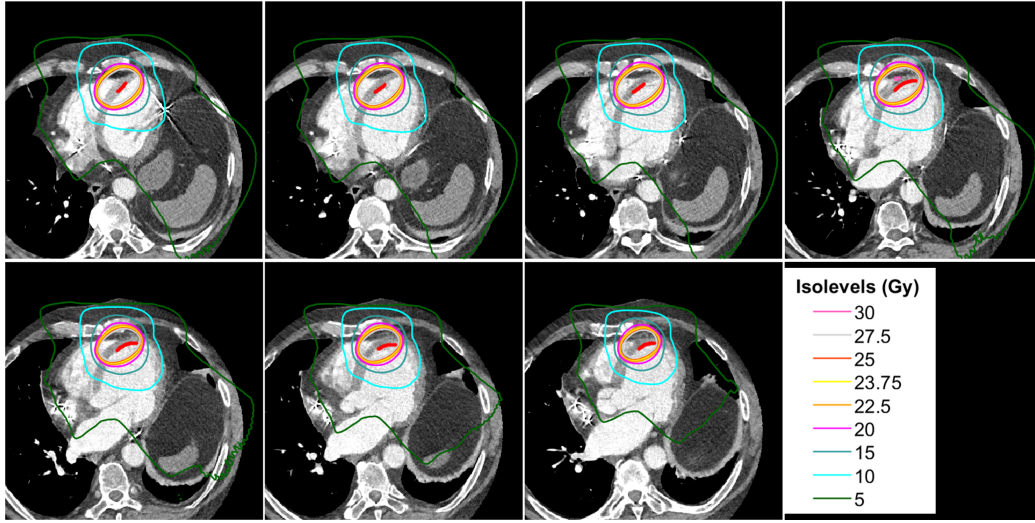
Representative case of the dose calculation visualization with the 2D-3D registered ventricular tachycardia target points (red) on the cardiac computed tomography slices in axial view.
